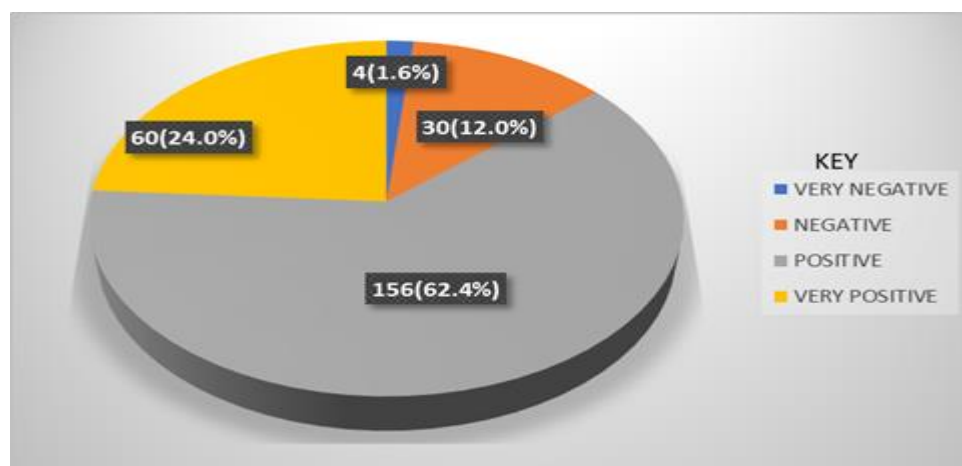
Distribution of obstetric ultrasonography experiences score category (n=250).
